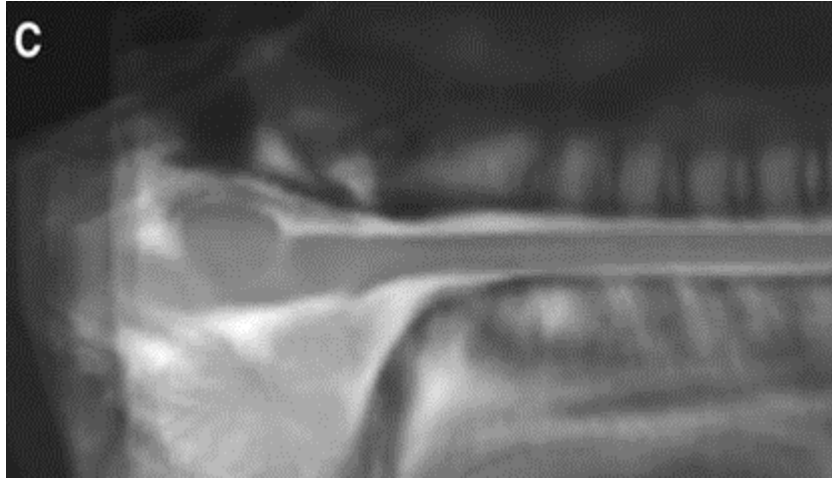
shows the midline slice averaged over 24 experiments in eight volunteers. (adapted from P. Stroman et al., Magnetic resonance imaging 26.6 (2008))
